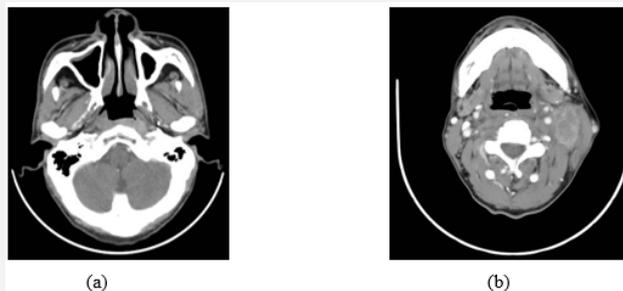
Pre-treatment enhanced CT image of NPC (a); and lymph node metastasis at level II, III with inside necrosis (b).
